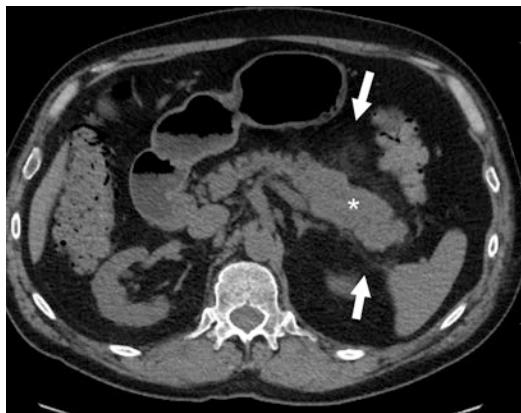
Drug-related pancreatitis due to pazopanib. A 56-year-old male with synovial sarcoma of the thigh with lung metastases. The patient had received ifosfamide and adriamycin in the past and recently initiated pazopanib daily for 4 months since the diagnosis of lung metastases. Axial CT after 4 months of pazopanib shows enlargement of the distal portion of the pancreas (*star*) with adjacent peripancreatic stranding (*arrows*), findings suspicious for drug-related pancreatitis
